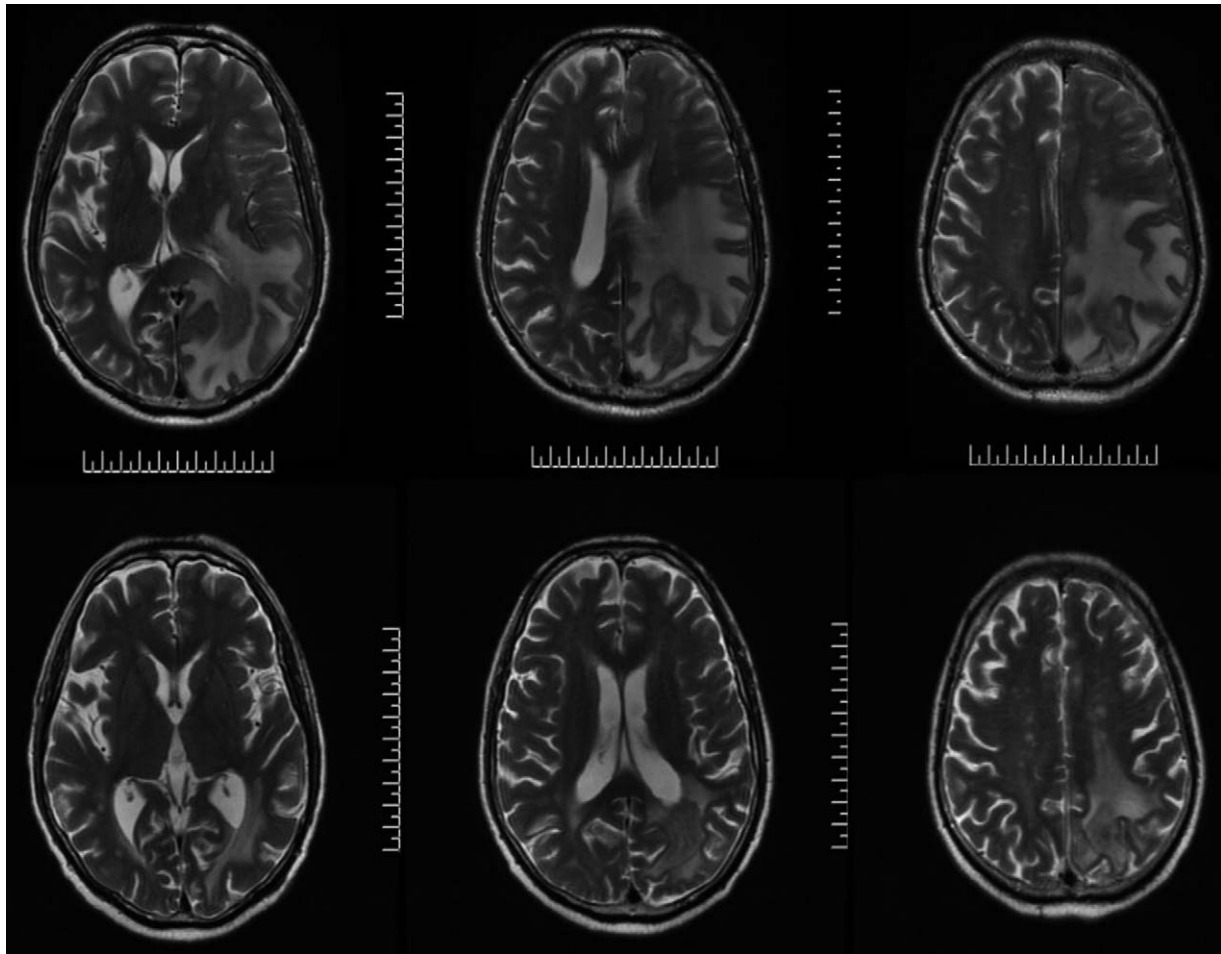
The 3 pictures above display T2-weighted MR of case 1 before treatment of apatinib, while the 3 pictures below indicate T2-weighted MR of case 1 after treatment of apatinib. Before apatinib administration, T2-weighted MR revealed large perilesional edema in the left parietal lobe. Four weeks after treatment with apatinib, T2-weighted MR showed that edema shrank obviously.
